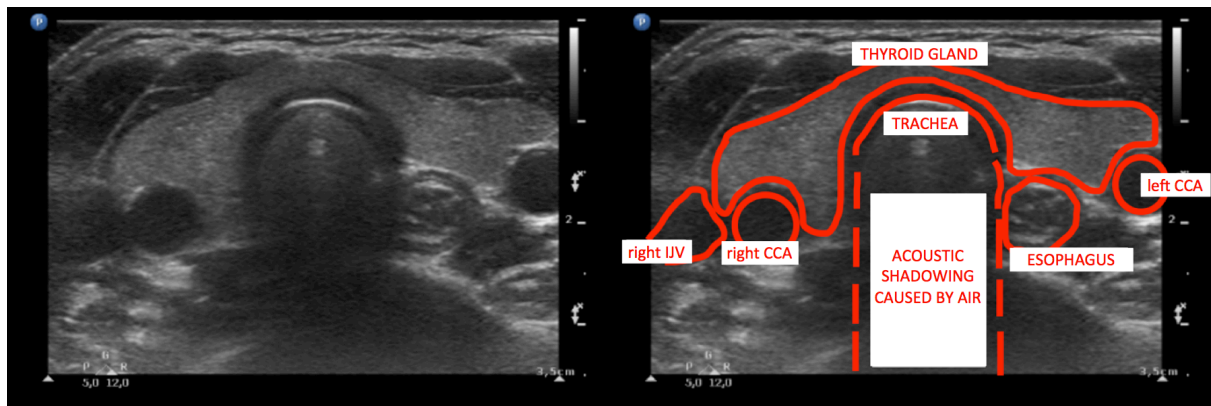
Ultrasonic examination of the cervical region – transverse (horizontal) plane.
